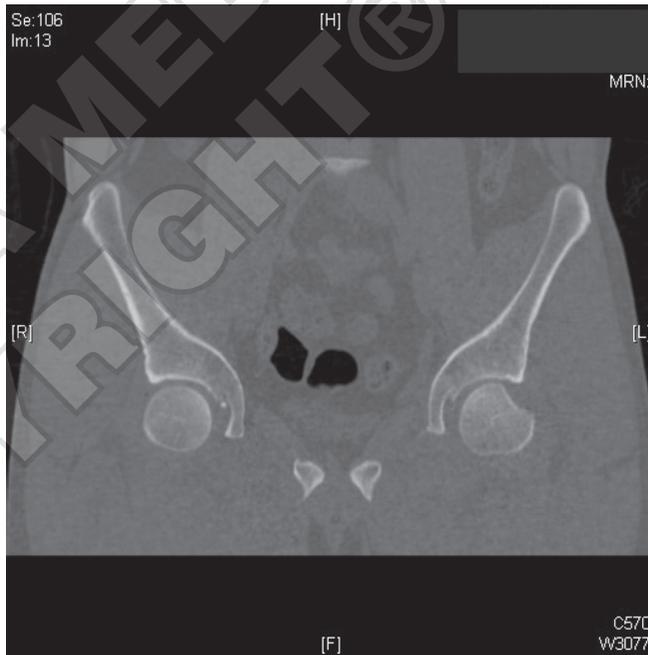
CT scan showing a Hill-Sachs-type injury in the left femoral head.
